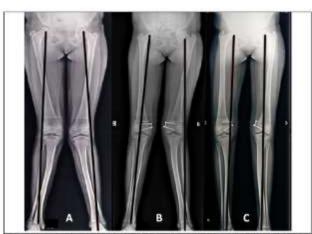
(Patient 15: 13 Years/ Female) Standing AP Radiographs Showing the Deviation of the Mechanical Axes: Pre-operative (a); 6 Month Follow-up (b); 12 Month Follow-up (c)
